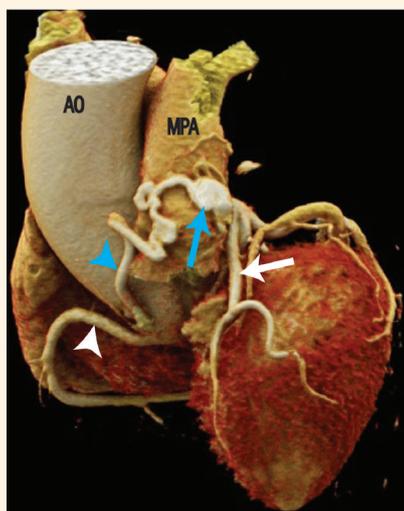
Three-dimensional volume rendered coronary computed tomography angiography image showing a tortuous vessel (blue arrowhead) arising from the right coronary artery (white arrowhead). The tortuous vessel passes anterior to the main pulmonary artery and forms a small aneurysm (blue arrow) before it enters the main pulmonary artery distal to the valve. The left anterior descending artery is marked by the white arrow.
